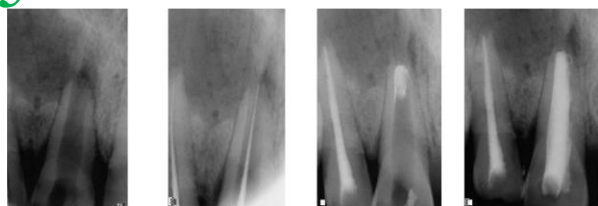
Preoperative radiograph of the maxillary right central incisor. Fig B: Working length determination. Fig C: Placement of the MTA apical plug. Fig D: Canal obturation after induction of apical barrier.
